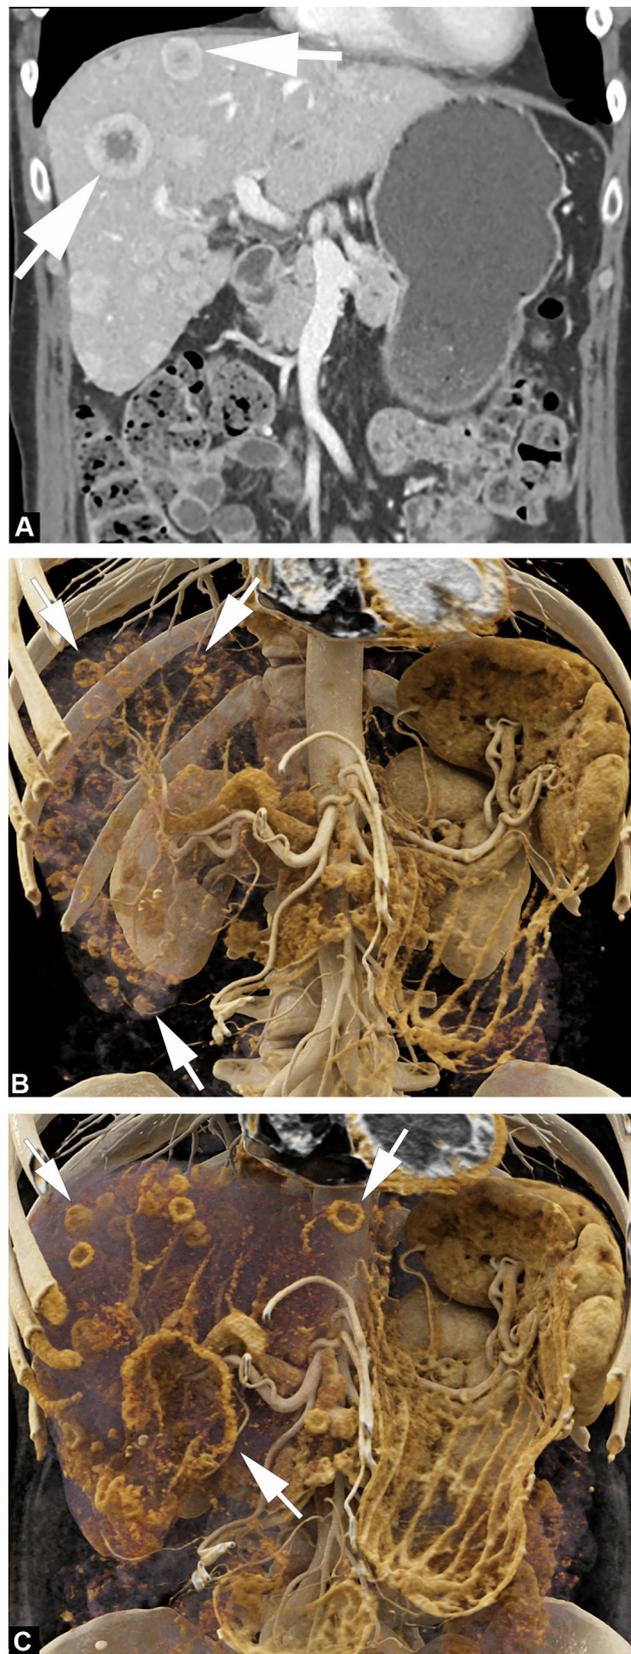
A 61-year-old woman with metastatic cholangiocarcinoma. A. Two-dimensional CT image obtained in the coronal plane during the portal venous phase of enhancement shows multiple enhancing liver masses with target appearance (arrows). B & C. CT images obtained in the coronal plane during the portal venous phase of enhancement with cinematic rendering can render the background liver translucent to highlight the global disease burden (arrows).
